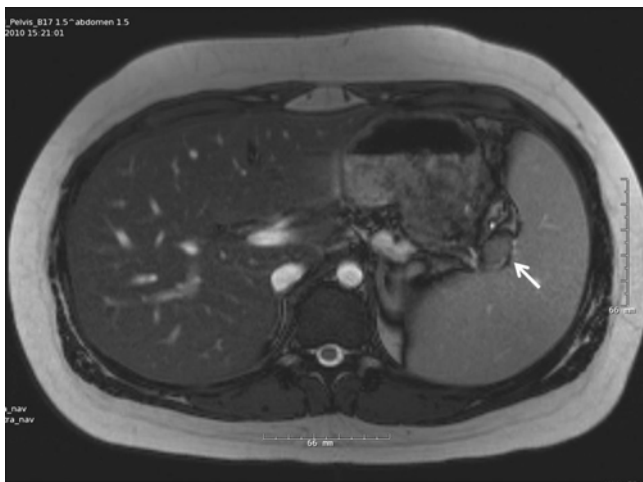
Abdominal MRI of a 13-year-old male with MEN1 showing a relatively large insulinoma in the splenic hilum. This patient had multiple synchronous smaller insulinomas and glucagonomas
